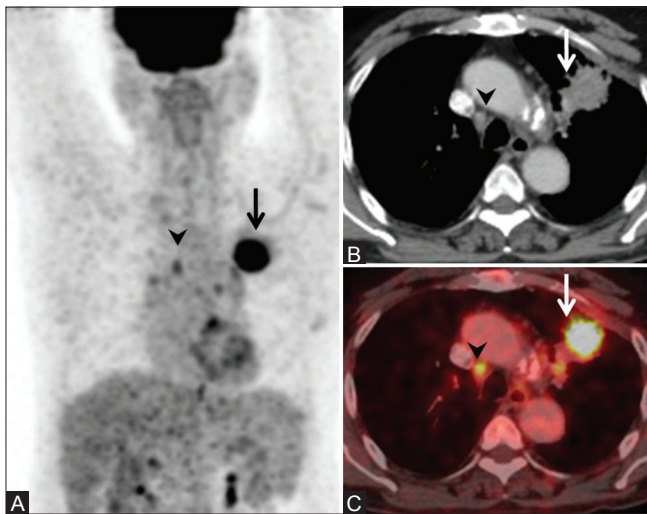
(A-C): FDG PET in nodal disease. Maximum intensity projection (MIP) image shows an FDG-avid primary lung tumor on the left side (arrow, A) and a focus of FDG uptake in the mediastinum (arrowhead, A). CT scan shows enhancing, spiculated primary tumor (arrow, B) and a small right paratracheal node (arrowhead, B) which is negative by size criteria. Fused PET/CT image shows FDG concentration in the primary (arrow, C) as well as the node (arrowhead, C), suggesting metastatic involvement. Mediastinoscopy and biopsy revealed metastatic node-N3 disease
